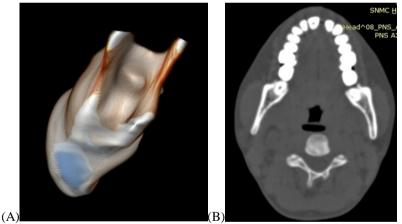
3D Imaging irt 11 using spiral CT (A;Sagittal and B;axial view)
